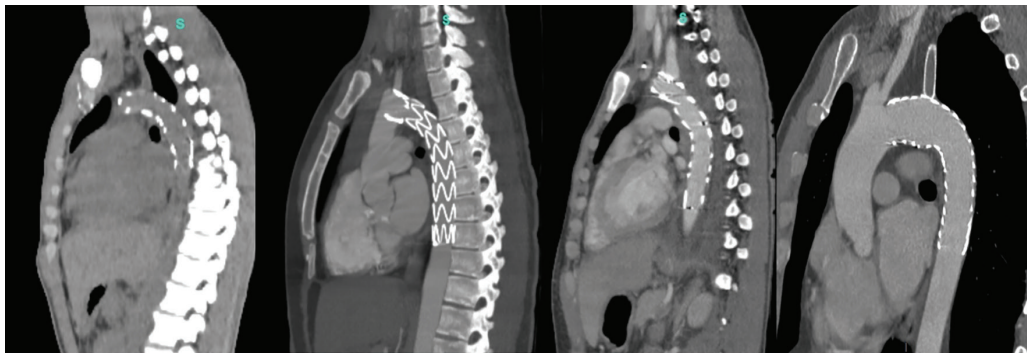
Sagittal CT angiography showing grade III BTAI post-TEVAR in patients 1-4.
